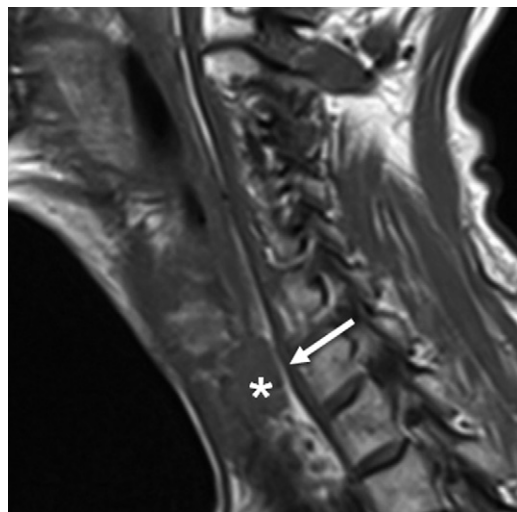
Sagittal T1-weighted image in a patient with a small postcricoid SCC of hypopharynx (asterisk). Preservation of high signal intensity retropharyngeal fat (arrow) is strong evidence that there is no invasion.
